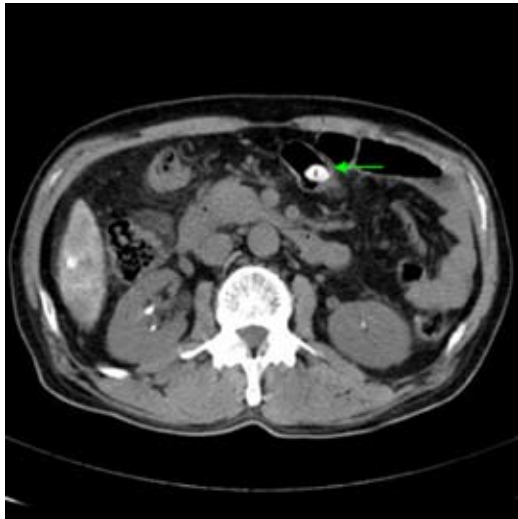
Pre contrast study CT scan demonstrating hyperdensity spot (green arrow) in the intestine.
